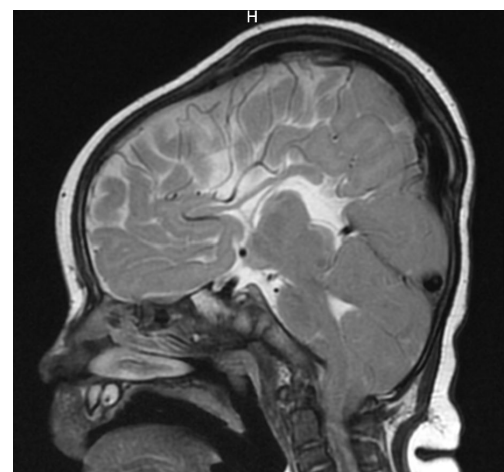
MRI brain showing Chiari malformation
